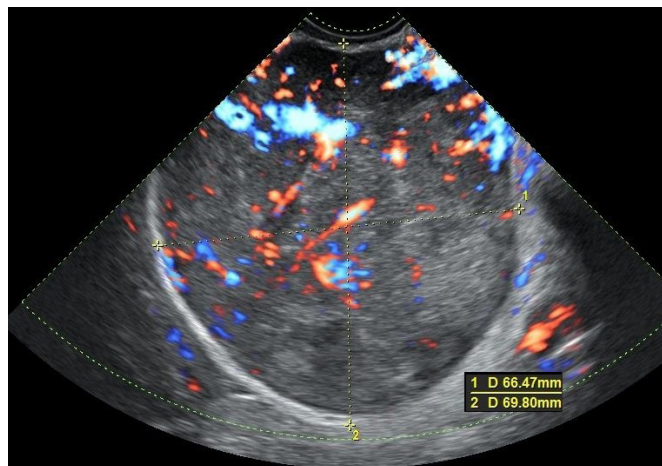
Ultrasonography (US) image of a uterine tumor with US markers suggestive of abnormality/malignancy. Solitary non-homogenous tumor with rich inner vascularization and absence of calcification and fan-shaped shadowing.
